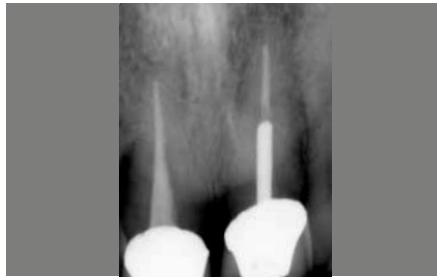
Starting radiograph.
